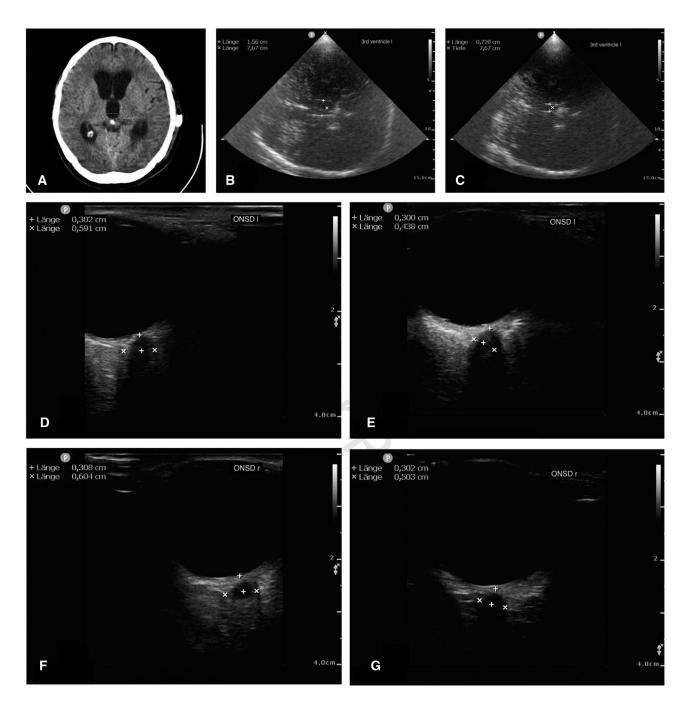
A 56-year-old female patient with a ventriculoperitoneal shunt following subarachnoid hemorrhage from a right posterior inferior cerebellar artery aneurysm and hydrocephalus occlusus, resulting in tetraparesis and severe neuropsychological defects. (A) CT at admission to the weaning and early neurorehabilitation unit showing a significantly dilated third ventricle (14.7 mm). (B) Transcranial B-mode sonography (TCS) on day 6 after admission: an increase in ventricle width to 15.6 mm. (C) TCS follow-up after 13 days of therapy (LP and shunting): width of third ventricle within normal parameters (7.3 mm). After therapy, the patient exhibited cognitive and motor improvements. Transorbital B-mode ultrasonography in the same patient: D (left) and F (right). Transorbital measurement of the ONSD day 6 after admission shows pathological values (5.9 mm, left eye; 6.0 mm, right eye). E (left) and G (right) Follow-up after 13 days of therapy (LP and shunting): width of the ONSD within normal parameters (4.4 mm, left eye; 5.0 mm right eye).
